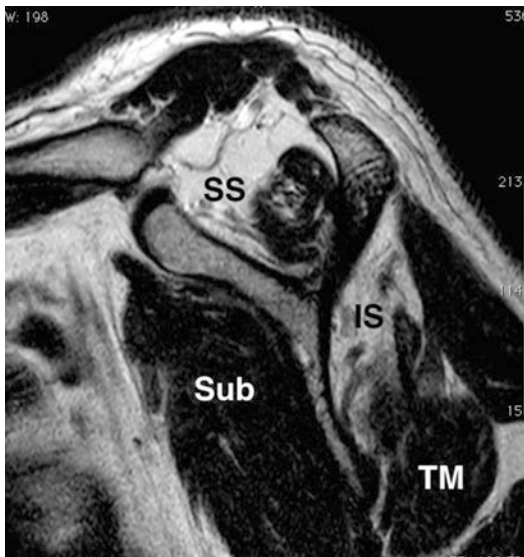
Sagittal magnetic resonance image T2 weighted of a shoulder demonstrating a fatty infiltration of the supraspinatus and infraspinatus muscles. *IS* infraspinatus muscle, *SS* supraspinatus muscle, *Sub* subscapularis muscle, *TM* teres minor
